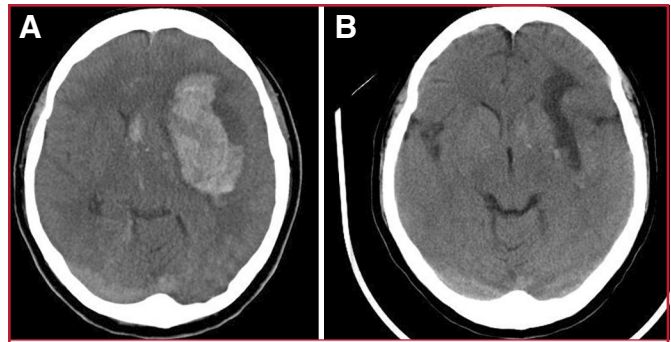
A, preoperative CT scan showing a left putaminal hemorrhage in a patient affected by moyamoya disease. This woman, presenting at admission with a Glasgow Coma Scale score of 14, suddenly became comatose and anisocoric during angiography and was operated on after emergency intubation. B, postoperative CT scan confirms complete hematoma removal.
